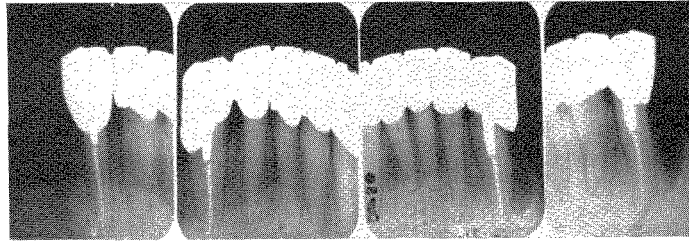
Roentgenograms taken in 1962 after the removal of the lower left first bicuspid root and the splinting of the lower six anterior teeth.
